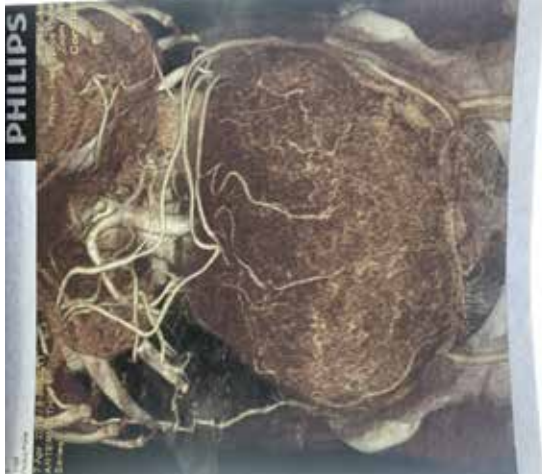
CT angiography showing mass with anonymous branches of superior mesenteric artery with multiple collateral vessels and multiple feeders supplying the mass.
